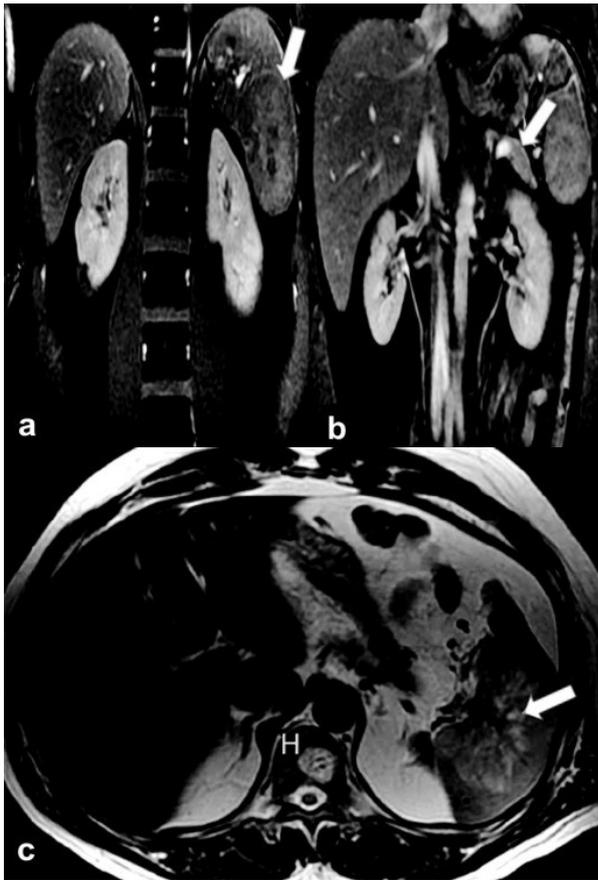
Intrasplenic insulinoma. FATSAT T1-MRI sequence with gadolinium. Intrasplenic lesion (a. arrow). Distal pancreatic tail without neoplastic infiltration (b. arrow). Axial MRI intrasplenic lesion (c. arrow).
